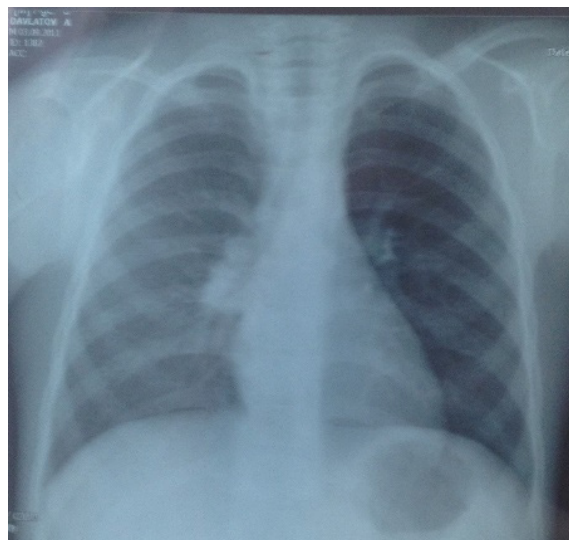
Chest x-ray at the admission of the patient (10 years of age). In the projection of the right lung root, a 4-cm diameter roundish formation with an irregular shape was observed. Pneumatization of the lung tissue was not impaired, and there was no displacement of the mediastinal organs
